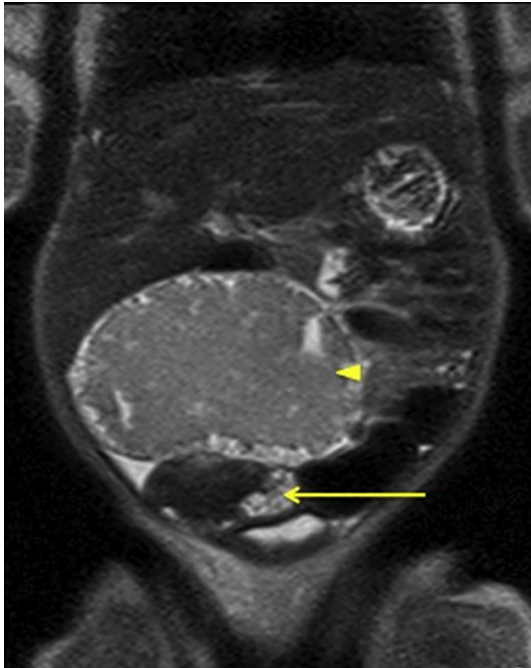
MRI demonstrating bilateral ovarian masses. Arrowhead: left ovary. Arrow: right ovary.
